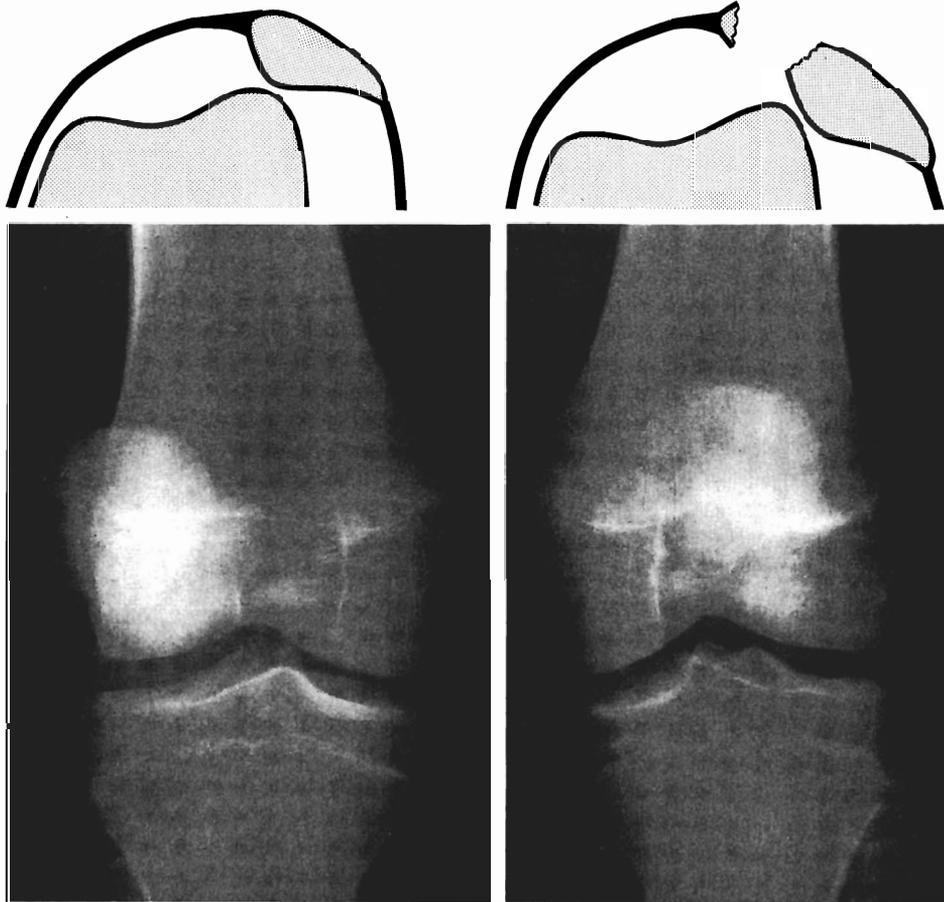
Acute dislocation of the patella. Usually the dislocation reduces before the radiograph is taken. Girl aged 13 years.
